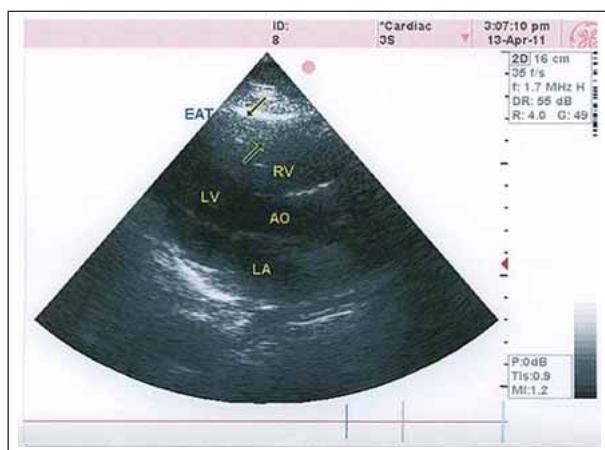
Transthoracic echocardiography showing a large area of epicardial adipose tissue (EAT) on the free wall of the right ventricle (arrows).
